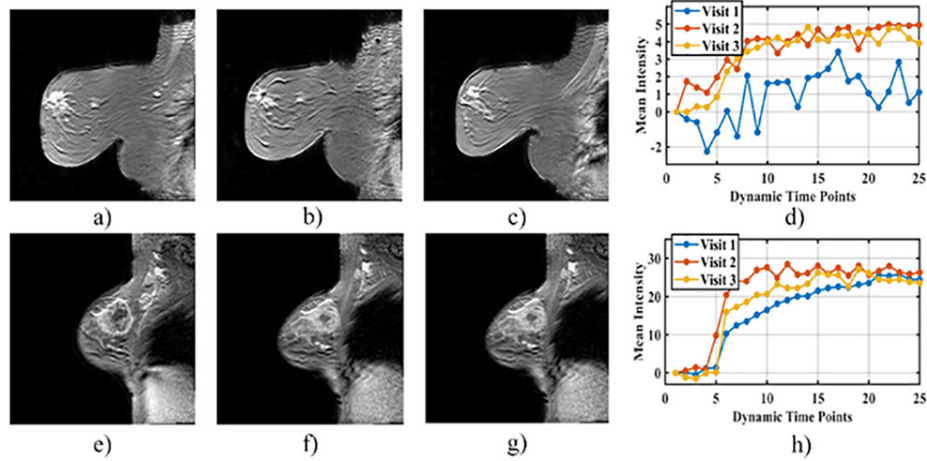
(a-h) DCE-MR images of two non-PCR patients represented in each row at Visit 1 (column 1), Visit 2 (column 2), Visit 3 (column 3), and corresponding time points versus mean intensity curves (column 4)
